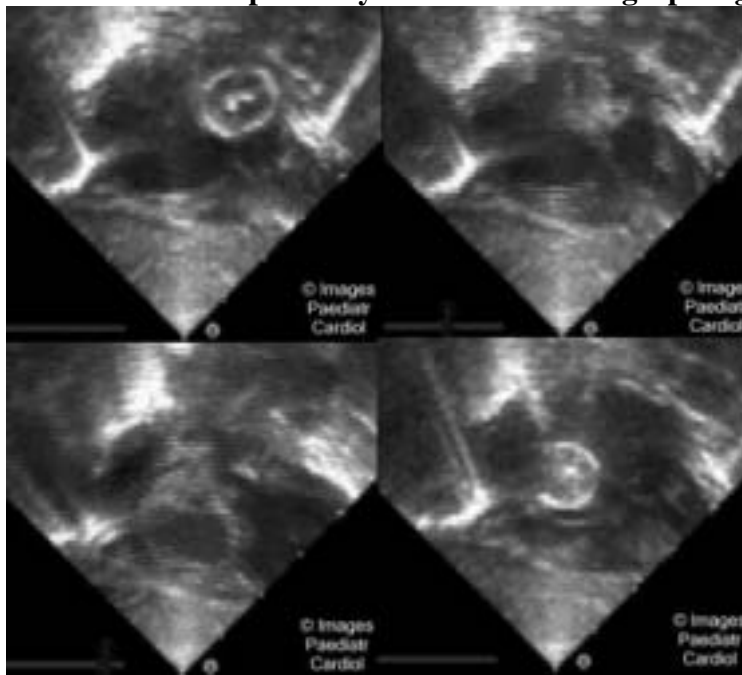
Balloon atrial septostomy under echocardiographic guidance.
